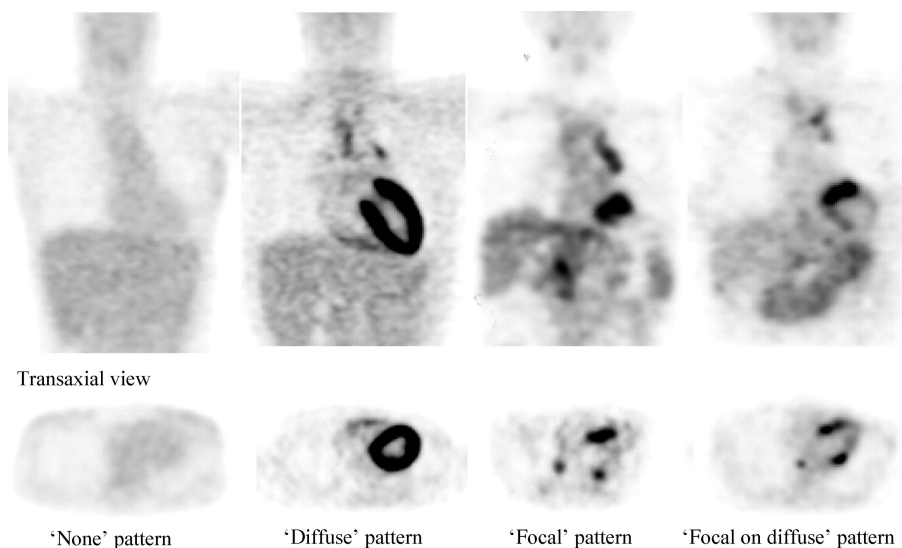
Four patterns on ¹⁸F-FDG PET images. The top images are coronal slices and the bottom images are transaxial slices through the heart. The none pattern indicates no myocardial uptake of ¹⁸F-FDG, and the diffuse pattern indicates that the outline of the LV wall was visually identified. The focal pattern was assigned when only focal uptake of ¹⁸F-FDG was observed, and the focal on diffuse pattern indicates focal ¹⁸F-FDG uptake overlying the diffuse pattern described earlier.
